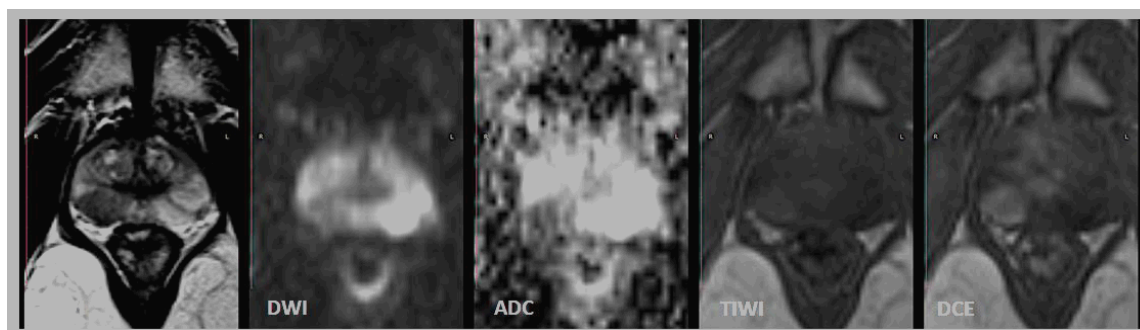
A 70-year-old male patient who had a high PSA level revealed a focal lesion in the right posteromedial/posterolateral mid-peripheral zone, along with positive DCE, homogeneous T2 hypointensity, notable ADC hypointensity, and no DWI hyperintensity. Prostate cancer (PI-RADS-3 upgraded to PI-RADS-4).
